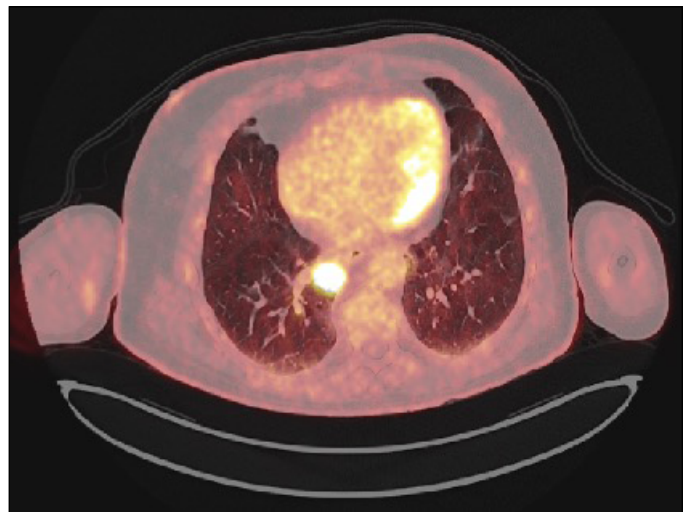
Positron emission tomography: hypermetabolic RLL paramediastinal nodule with a maximum standard uptake value (SUV) of 11.9, consistent with a primary pulmonary neoplastic process.
